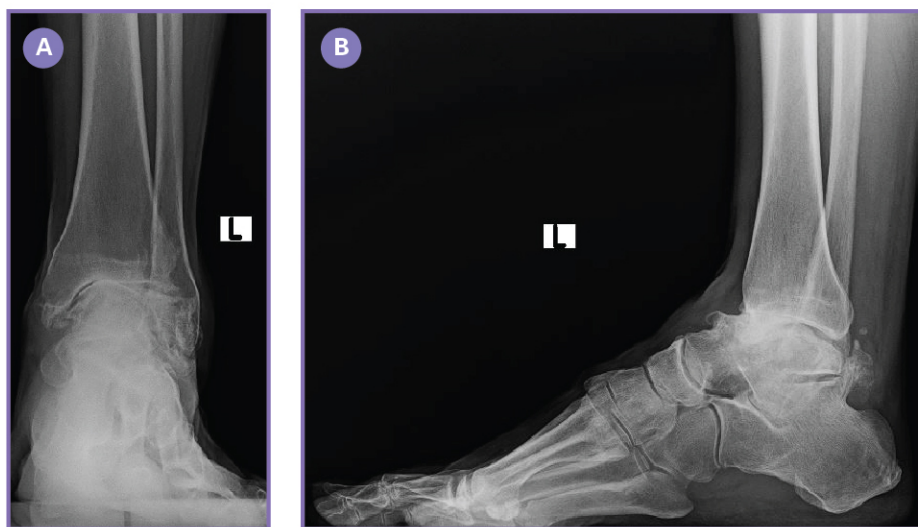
Weightbearing pre-operative radiographs demonstrating varus ankle arthritis with advanced concomitant subtalar joint arthritis (A) AP and (B) Lateral.
